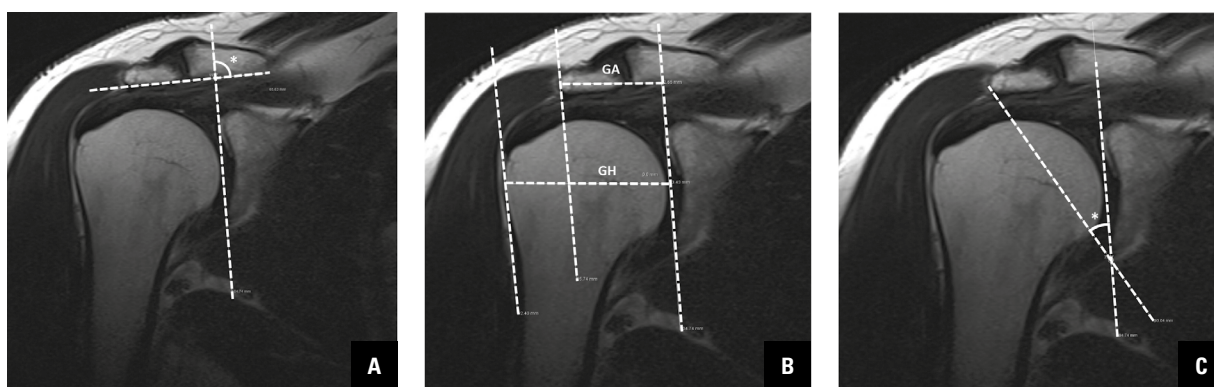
Parameters of acromial morphology in magnetic resonance imaging; A. Lateral acromial angle (*); B. Acromial index ($AI = GA / GH$); C. Critical shoulder angle (*).
